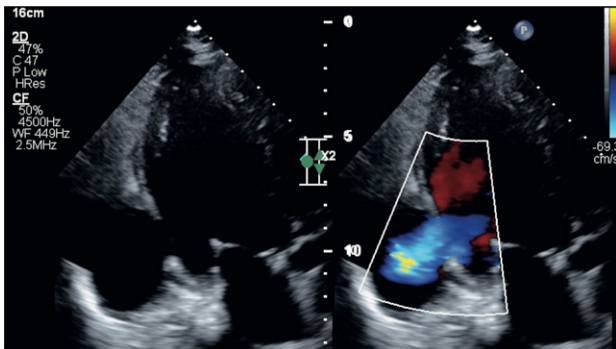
Transthoracic Doppler echocardiogram showing a blood-filled, thin-walled protrusion (*) from the posterolateral wall of the left ventricle (LV).
